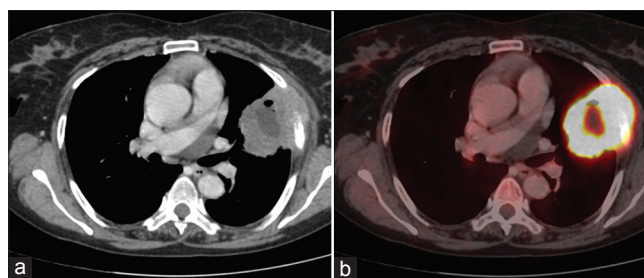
F-18 FDG PET/CT images (a) transaxial CT and (b) transaxial fused PET/CT of a patient with cervix cancer on follow-up showed an FDG avid mass lesion in the left lung, which was interpreted and confirmed to be a second primary
